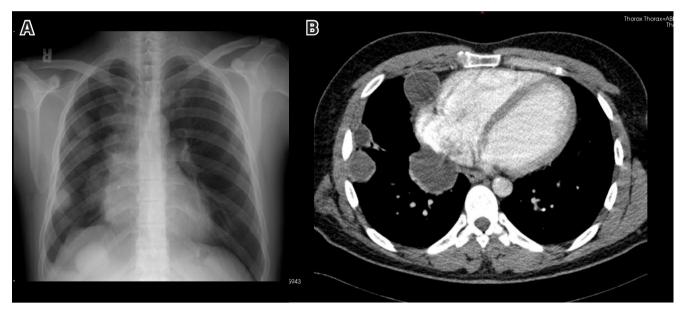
X-Ray image showing multiple cystic lesions in the right hemithorax (A), The computed tomographic appearance of multiple hydatid lung cystic (B).
